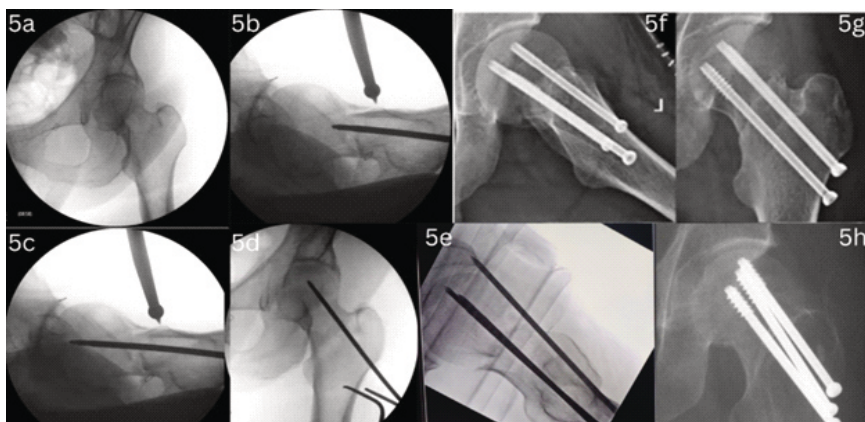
(a to f). - Showing steps of reduction and CC screw fixation. 5a, 5b, 5c - Reduction of ICNF fracture using ball tip spike. 5d, 5e - Temporary hold by K wire & placement of CC screw guide wire. 5f & 5g - Immediate post-operative X-rays. 5h - Post-operative 3 months X rays showing complete healing.
